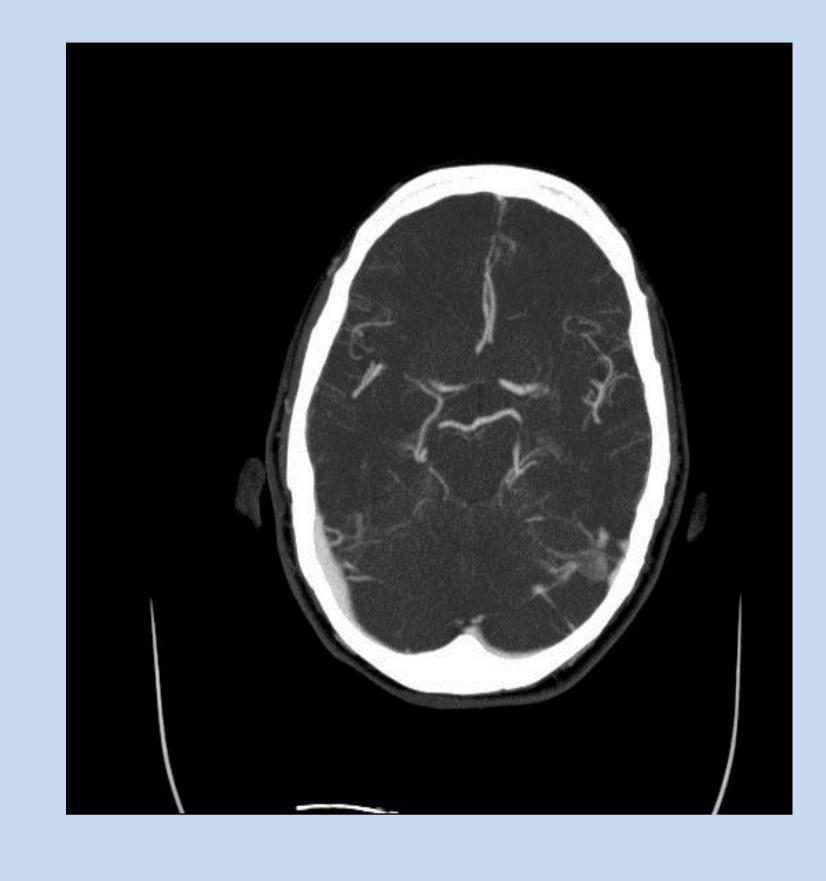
Normal brain CT angiography
